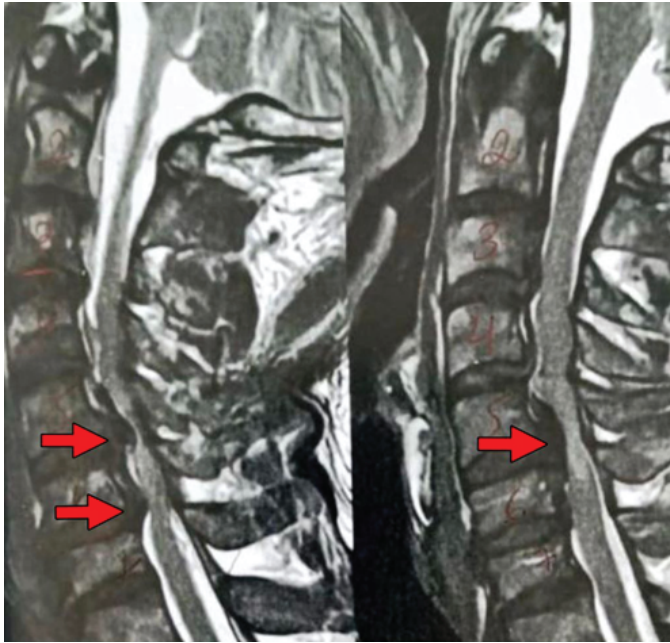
T2-weighted sagittal MRI of the cervical spine showing severe cervical stenosis at the C4-C5-C6 levels, significant disc protrusions at these levels, with signs of spinal cord suffering/myelomalacia.
